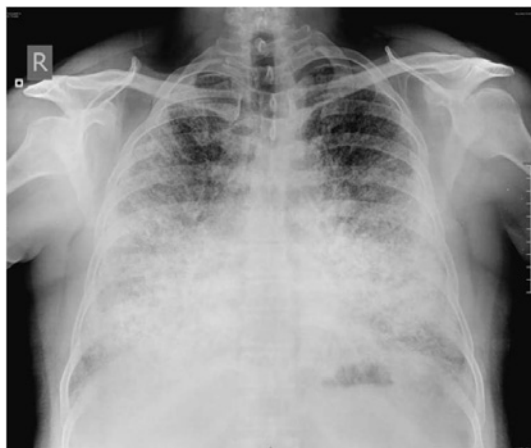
Chest X-ray showing diffuse bilaterally symmetric micronodular calcification (sand storm pattern) involving predominantly the middle and lower lung zones with obliteration of heart borders and the diaphragm.
